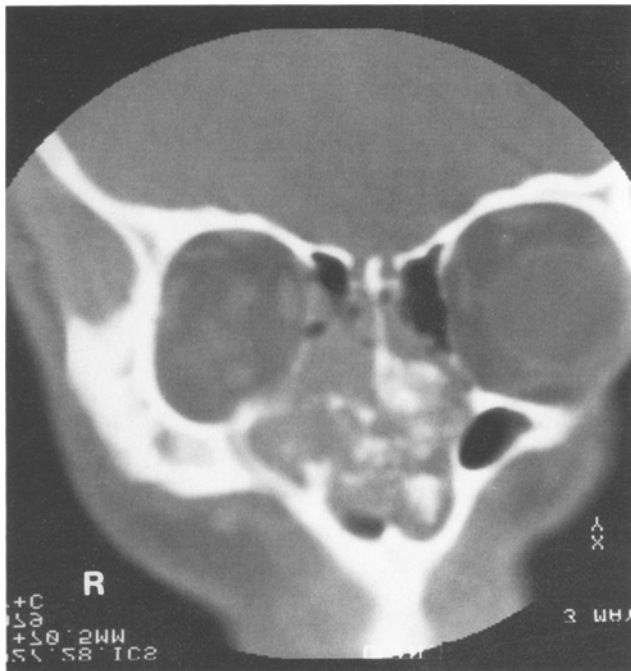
CT-scan of the tumour involving the nasal cavity, and extending to ethmoid, maxillary sinus and right orbit
